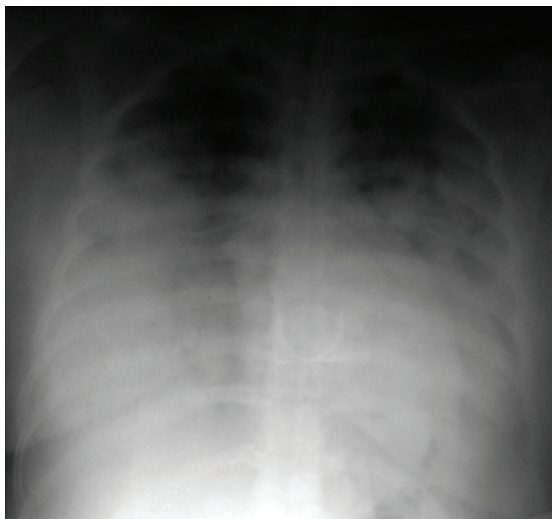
Chest radiograph in admission
